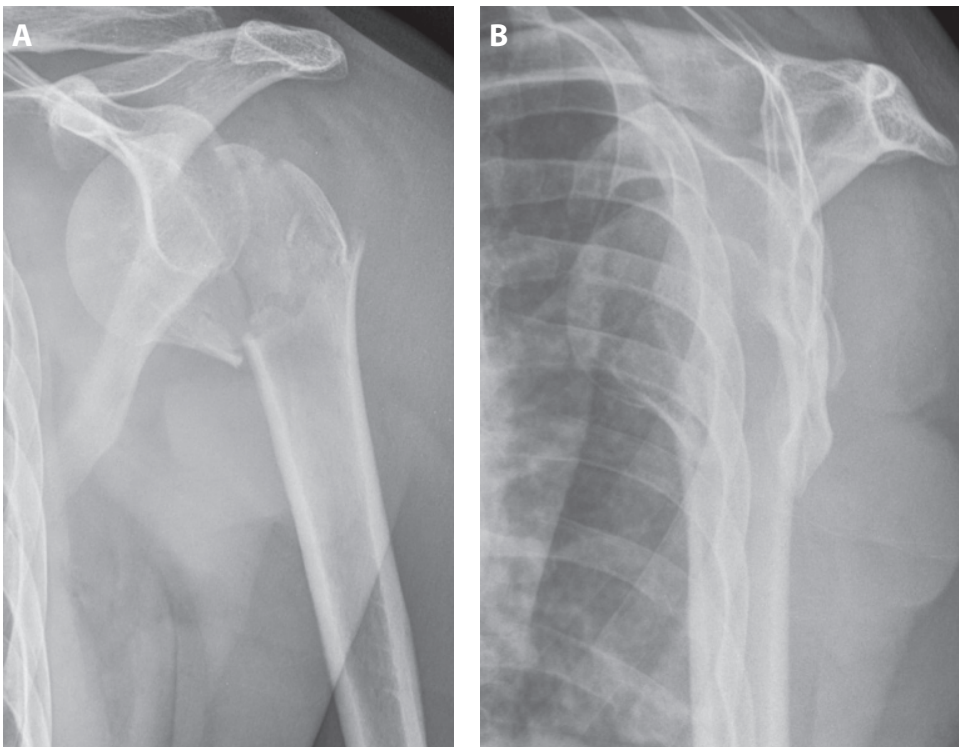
X-rays from anterior-inferior proximal humeral fracture-dislocation on AP (1a) and Neer (1b) view.
